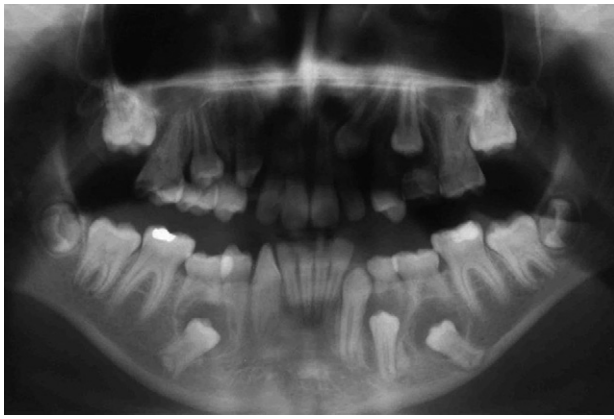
Radiography taken 2 years after the last one, where radiolucid lesions are observed around crowns of teeth 3.5 and 4.5, with displacement to their apical.
